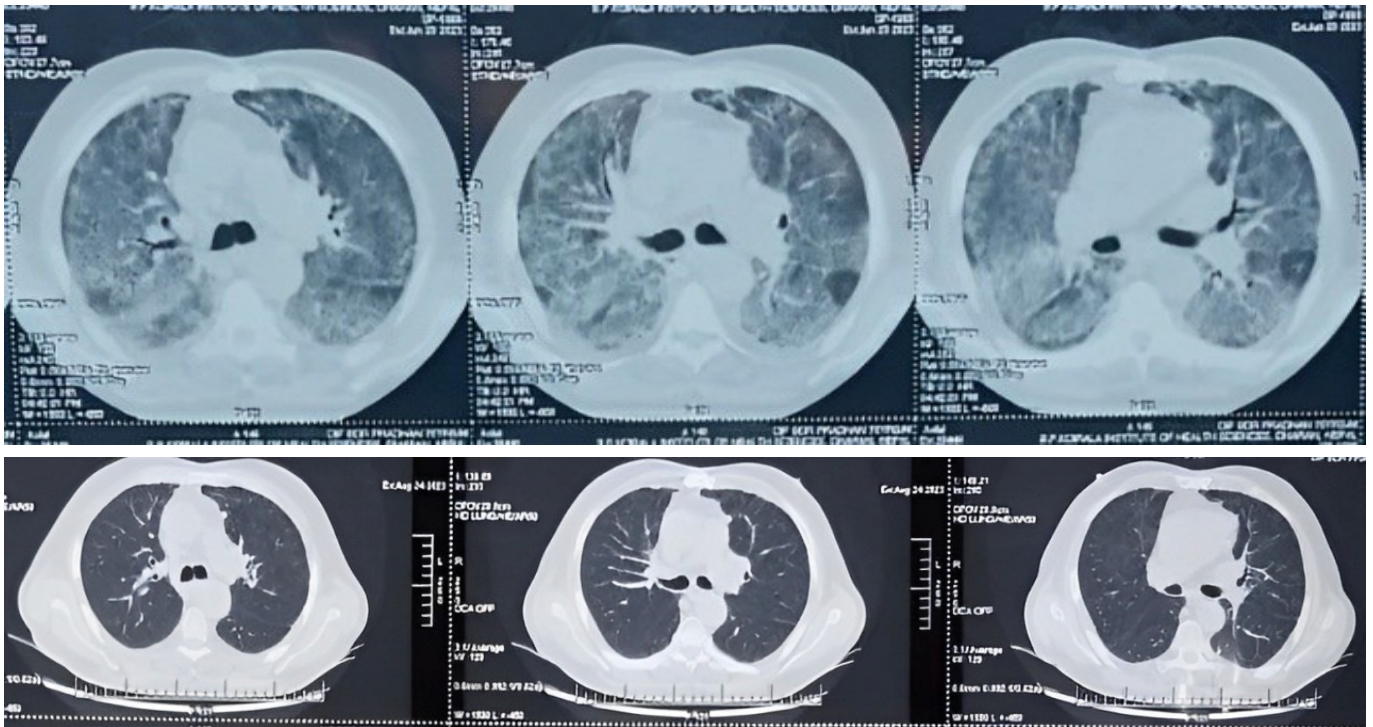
Comparing chest x-ray at initial presentation (1.A) and on follow up at 2 months (1.B) showing clearing of lung field without ground glass opacities (GGO)
